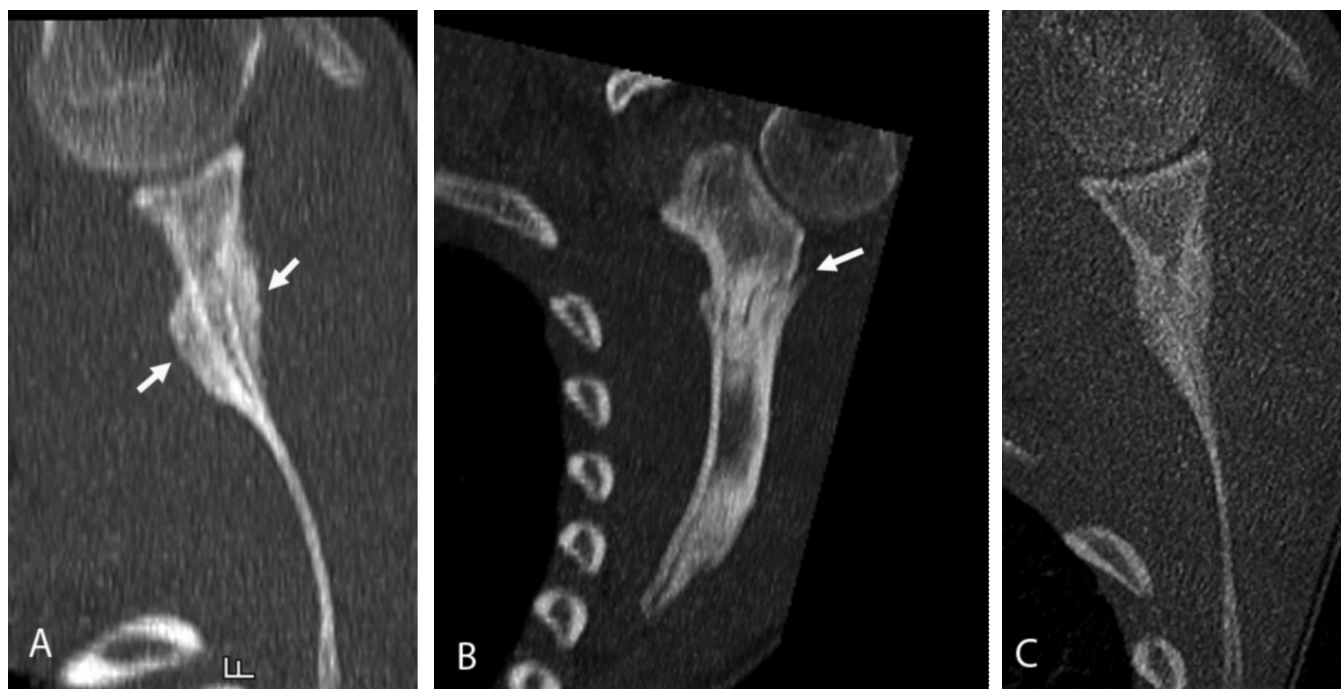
17-year-old male with scapular stress fracture. CT with bone-reconstruction algorithm shows a nonaggressive lesion with smooth periosteal reaction along the margins of the fracture (arrows in A). An oblique reformatted image reveals the fracture line as an oblique lucency through the neck of the scapula (arrow in B). A followup shoulder CT four weeks later shows interval healing of the stress fracture (C).
